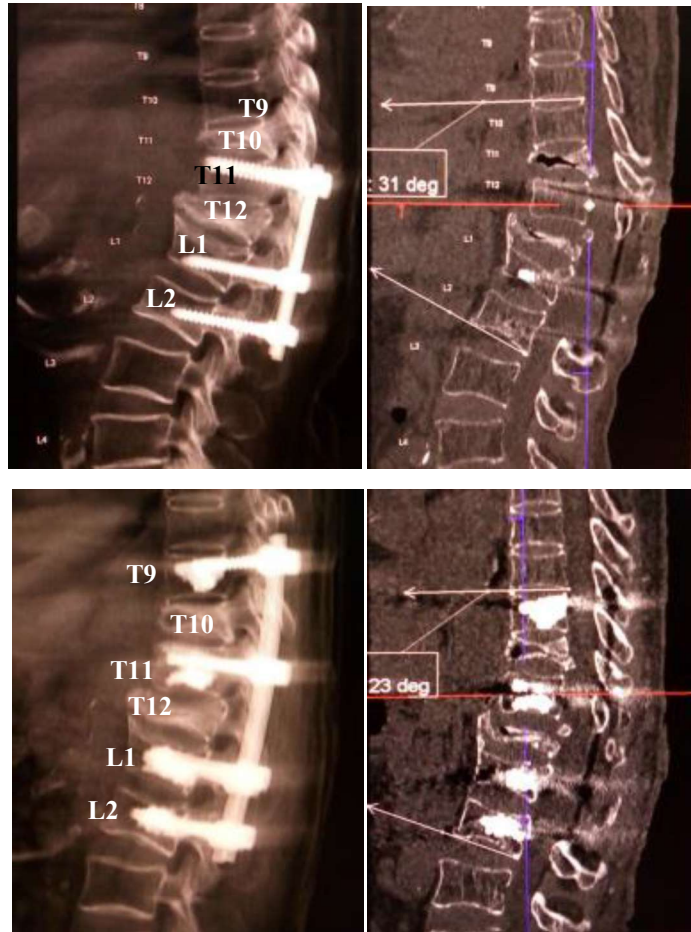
The patient had been operated once before due to the spinal compressive fracture. Above is the spinal CT scanner before the second surgery. He underwent another surgery for spinal fixation with PMMA augmented conventional pedicle screws to fix the kyphosis (below)
